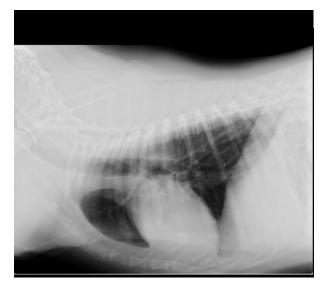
X-ray follow up performed 12 months after surgery confirmed the normal clinical course of the patient
